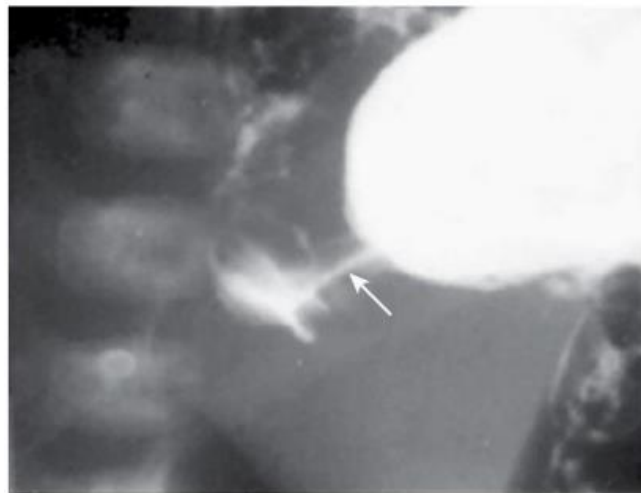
■ At some hospitals outside of urban centers, ultrasound technicians and radiologists proficient in performing an ultrasound study for pyloric stenosis are not available. Also, in some instances, an ultrasound study can be equivocal. An upper gastrointestinal series can be helpful in making the diagnosis of pyloric stenosis or confirming an equivocal ultrasound study. In this upper gastrointestinal study, note the 'string sign' indicating a markedly diminished pyloric channel (arrow) and subsequent gastric outlet obstruction. It is important to evacuate the contrast material after this study to reduce the risk of aspiration and pulmonary complications.
